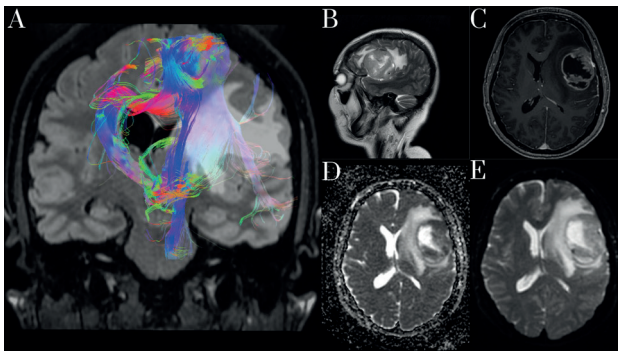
A: DTI- MRI was performed and revealed displacement of corticospinal tracts on the left with the total destruction of associative and commissural pathways. B: T2WI that demonstrates the tumor in the left frontotemporal region, involving the speech center. C: Post-contrast images demonstrate enhancement, notice there was also a 13 mm dislocation of central structures. D and E: ADC (D) and DWI (E) images demonstrate the presence of areas of pronounced restriction of the diffusion coefficient in the tumor stroma. It presumes necrotic tissue in the tumor, which indicates a high-grade tumor.
